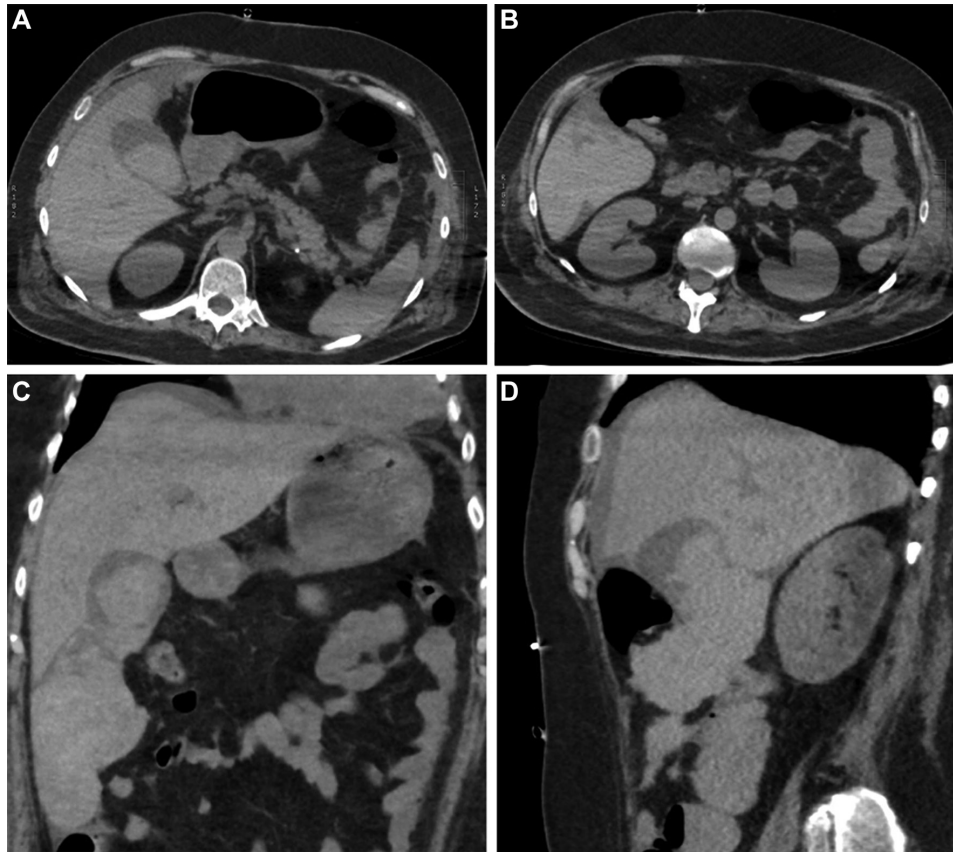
(A–D) Non-contrast helical CT abdomen in a 45-year-old male patient with abdominal pain, day 40 post-cardiac transplantation.
